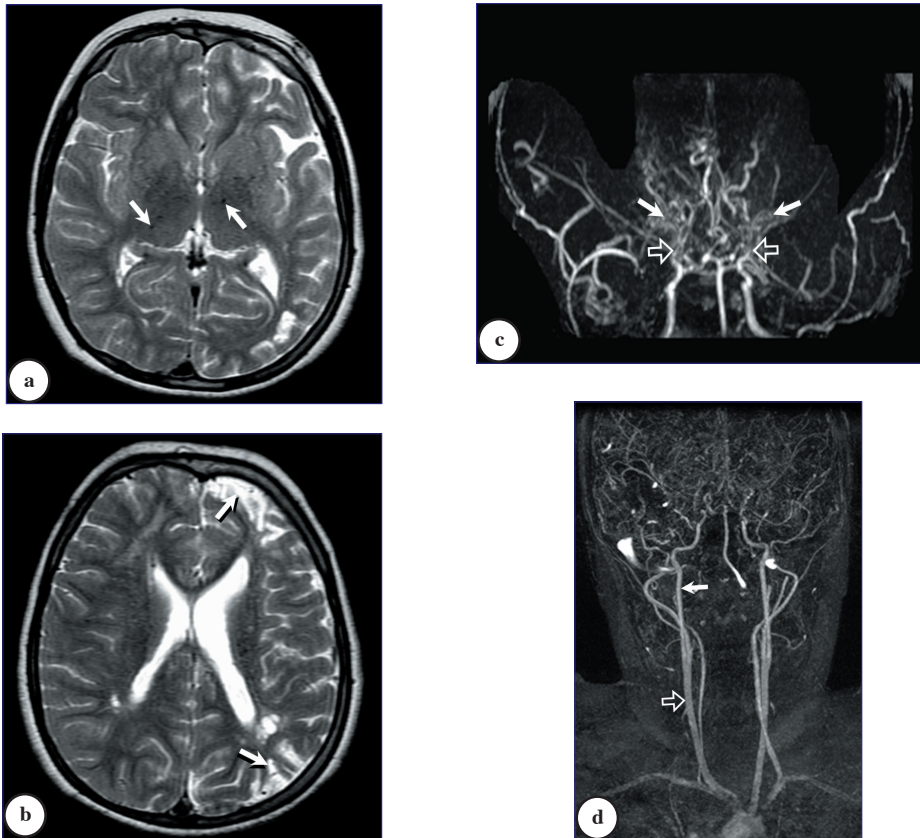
a) Axial T2-weighted image of the brain showing multiple signal void foci in the basal ganglia (arrows) due to enlarged thalamoperforate collaterals. b) Axial T2-weighted image of the brain showing multiple high signal intensity lesions at the left frontal and left parietal cortex (arrows) and in the white matter adjacent to the trigone of both lateral ventricles due to old infarctions. c) MR angiography showing occlusion of both internal carotid arteries at the distal supraclinoid segment (open arrows) with dilated thalamoperforate collaterals (arrows). d) MR angiography of the neck vessels showing normal caliber of the common carotid (open arrow) and cervical part of the internal carotid arteries (arrow).
